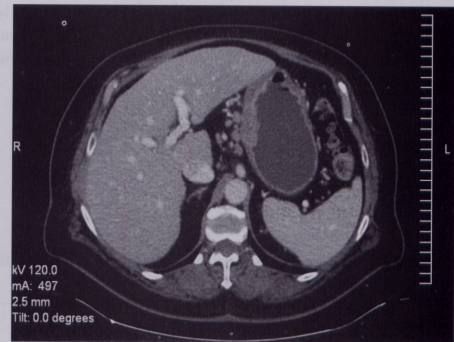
CT appearance of irregular thickening, partially mammelonated, of the posterior wall of the stomach body, associated with hyperplastic lymph nodes along lesser curvature of the stomach, liver hilum, and celiac, portacaval, and interaortocaval level, and splenomegaly.
